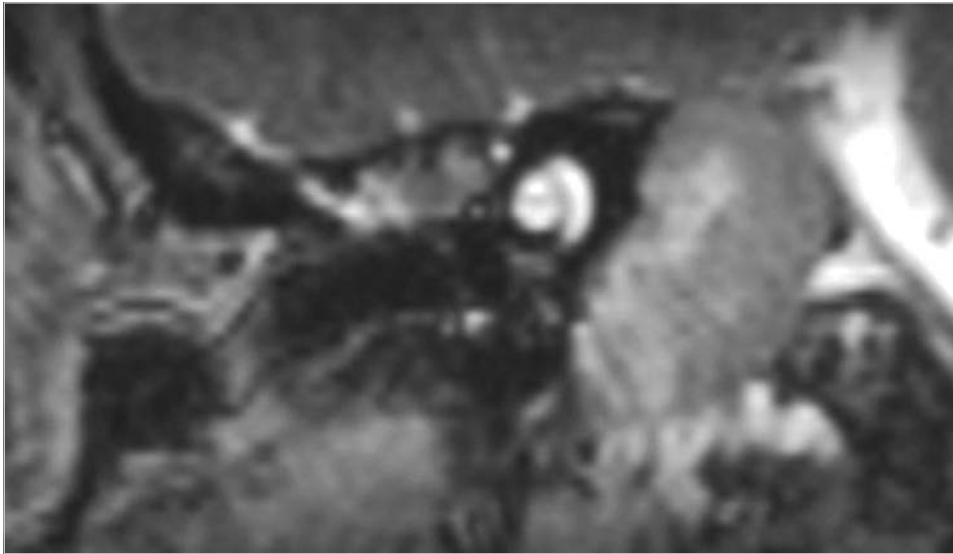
The coronal MRI image shows cholesteatoma occupying the petrous apex.
